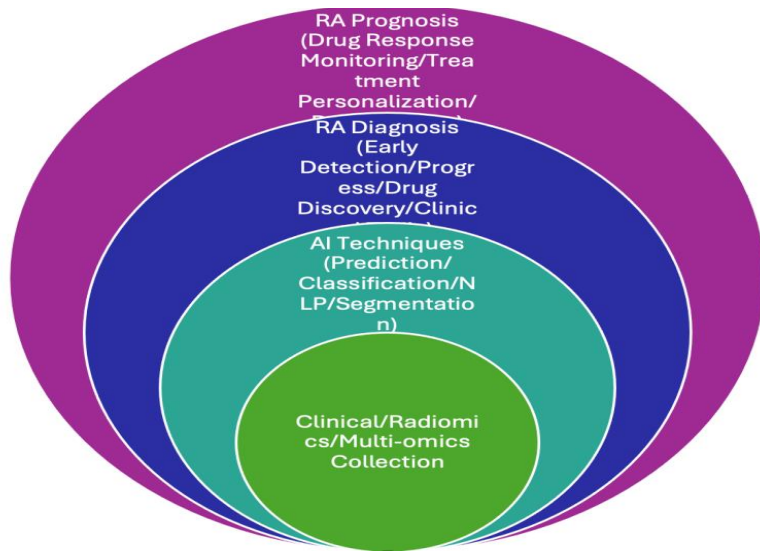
Artificial intelligence in the early diagnosis of diseases (RA). Data Collection: data is collected from X-ray images, electronic health records, drug information and multi omics data. Different Ai models are used for the diagnosis. Then final diagnosis and prognosis are provided by the used Ai techniques
